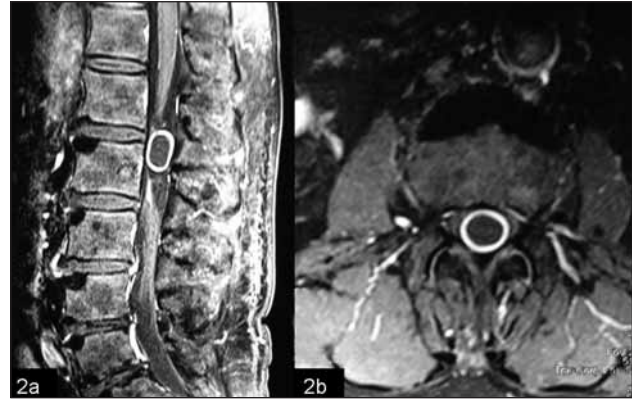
Characteristic ring enhancement is seen on post contrast sagittal (2A) and axial MR images (2B).
